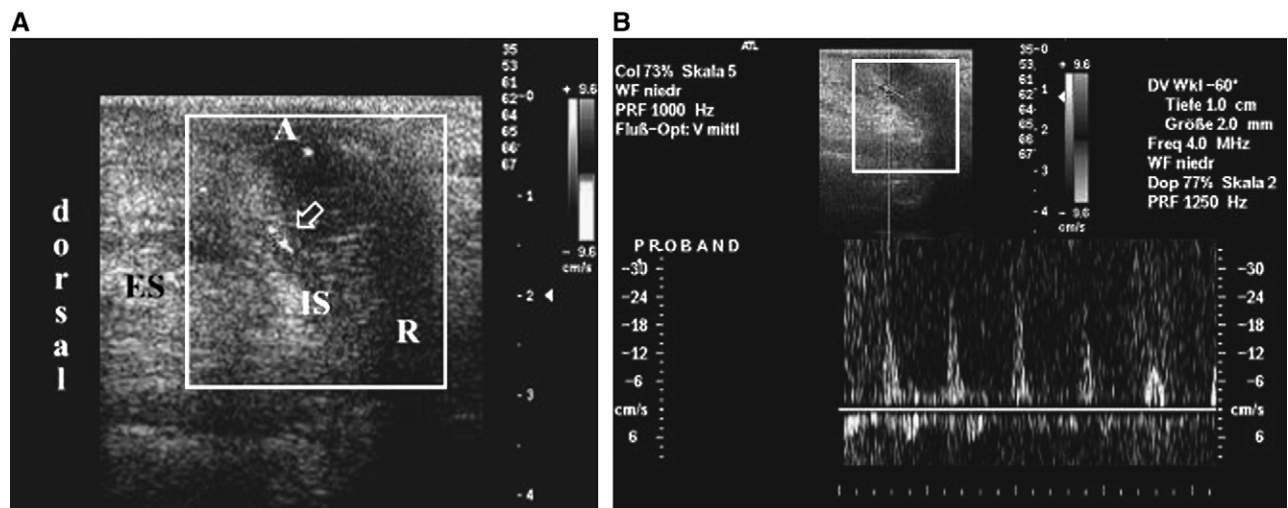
A 19-year-old male patient with no anorectal abnormalities; transperineal color Doppler ultrasound, longitudinal scan. (A) A dorsally situated terminal branch of the SRA is shown (*open arrow*) running through the rectal submucosa (caliber 1 mm). A, anal canal; R, rectum; IS, internal anal sphincter; ES, external anal sphincter. (B) Same patient and arterial vessel within the dorsal rectal wall. Doppler measurement of the arterial blood flow (21.0 cm/second).
